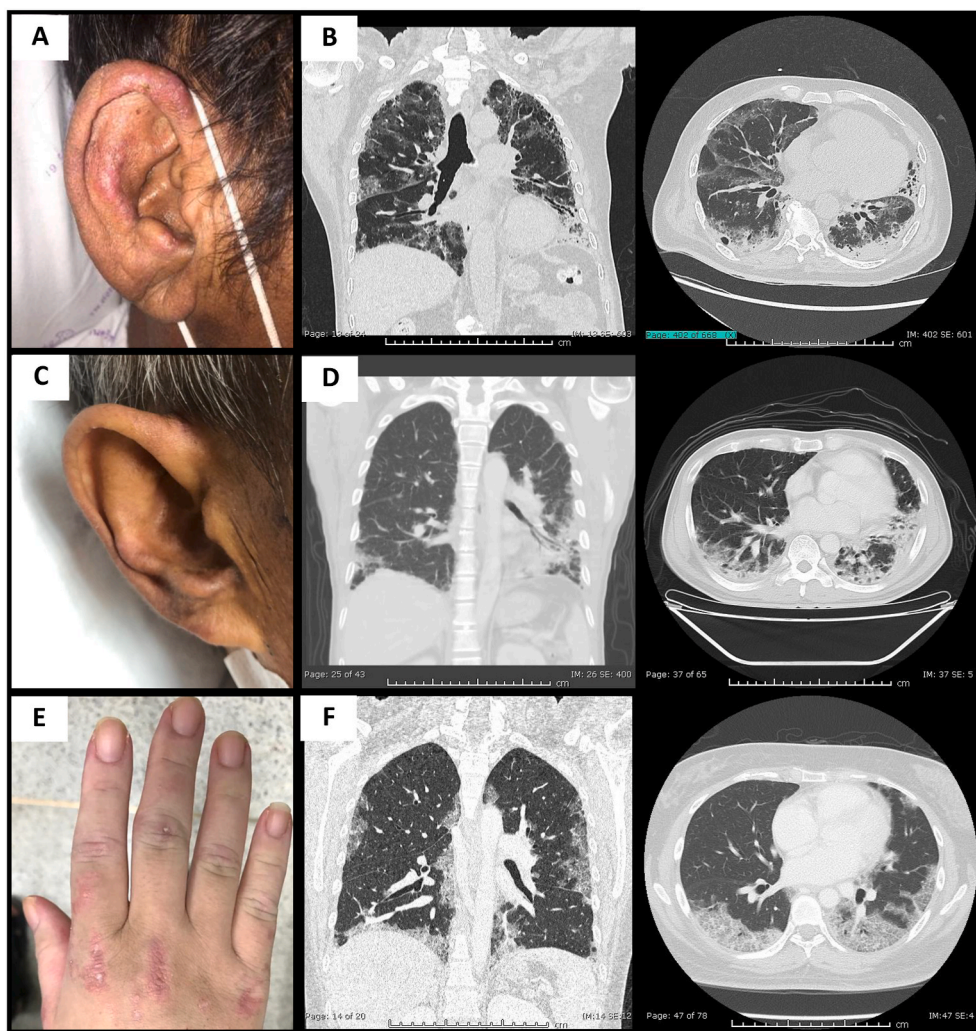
Images of patients with fatal RP-ILD in anti-MDA5 antibody-positive lung disease (A) erythematous auricular papules at helix and antihelix, and necrotic ulcer at anti-tragus area of right ear, and (B) chest HRCT finding of diffuse subpleural ground-glass opacity and predominately lower lung consolidation and reticulation (case 1), (C) erythematous rash at helix and antihelix of right ear, and (D) chest HRCT finding of bibasilar consolidation and reticulation (case 2), (E) skin ulceration overlying on the Gottron's sign over the right third knuckle, and (F) chest HRCT finding of subpleural ground-glass opacity and consolidation, with accompanied by pulmonary hypertension (case 3).
